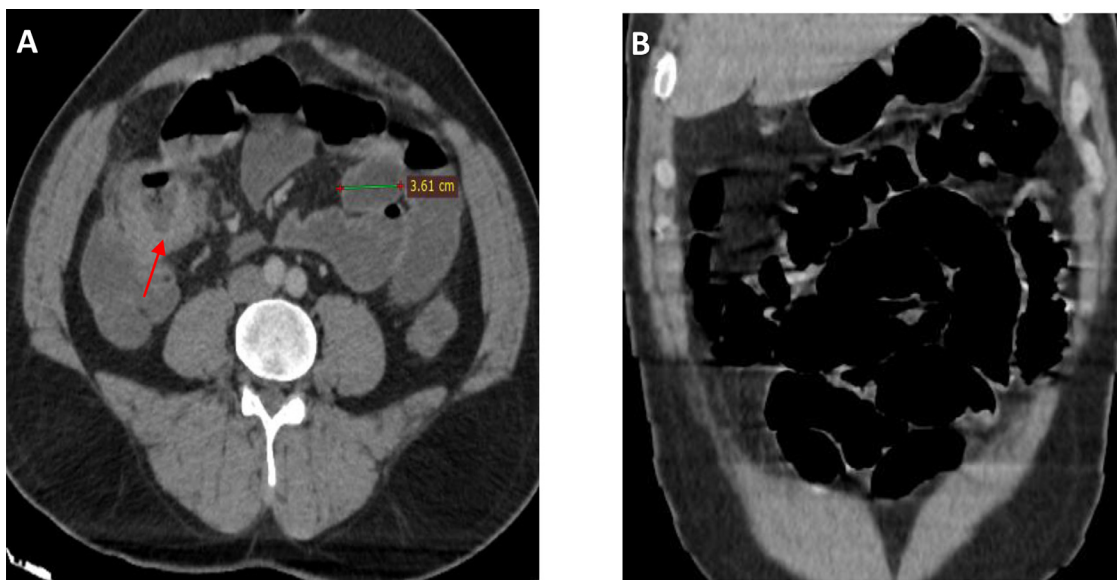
Abdominal CT scan after injection in axial (A) and coronal (B) sections: circumferential ileo-caecal mass (red arrow) enhanced after injection, associated with diffuse distension of the small intestines and hydro-aeric levels in relation to an occlusive syndrome.
